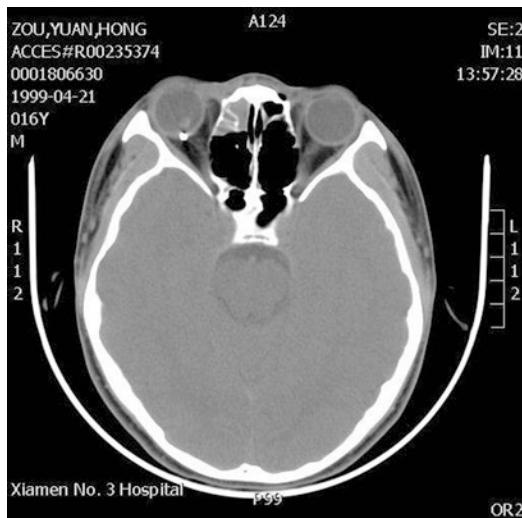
The CT scan showing the metallic foreign body just located at the posterior global wall
